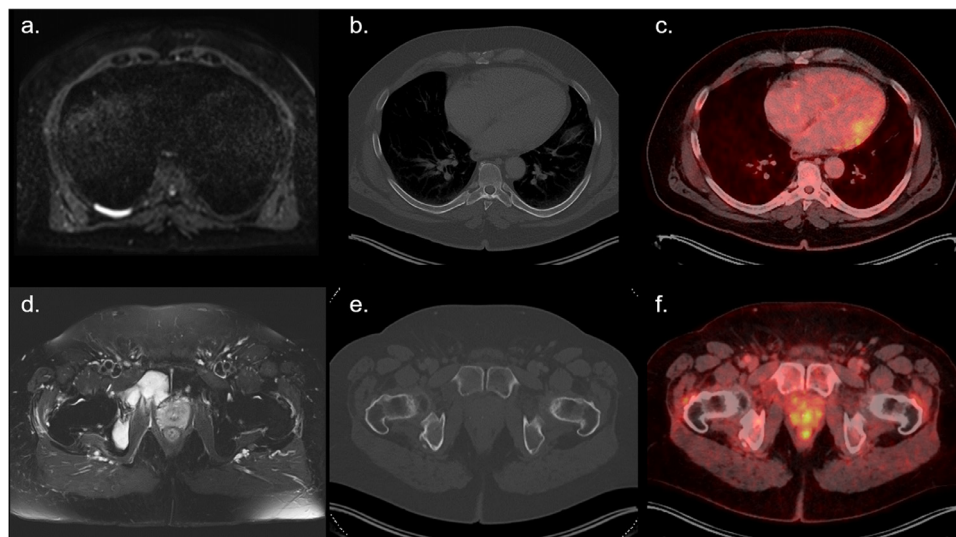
Myxoid liposarcoma. (A - F) 57 y/o male with myxoid liposarcoma metastases. (A) DWI and (D) T2 fs show increased signal intensity of osseous metastases in the right 8th rib and the right ischiopubic ramus. (B, E) CT and (C, F) fused ¹⁸F-FDG PET/CT without corresponding imaging changes.
